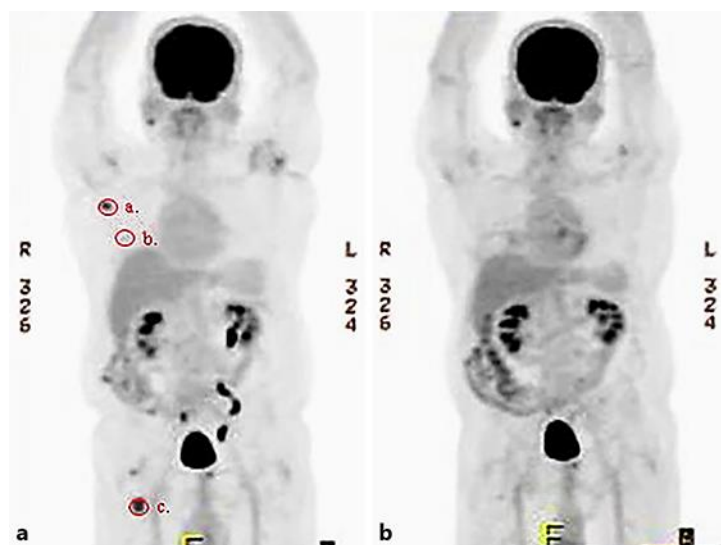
Target lesions on PET/CT before therapy (a) and after 18 months therapy (b). a., right axillary lymph node; b., right lower lobe pleural nodule; c., right proximal femur lesion.
